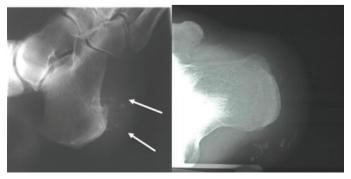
X-rays of left heel showing calcification on the medial aspect of calcaneum.
